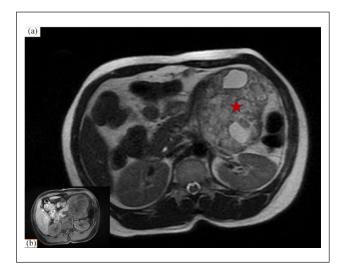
Pancreatic MRI: (a) Axial T2-weighted section showing a well-limited, encapsulated mass in the tail of the pancreas, with a dual component: cystic in frank hypersignal and tissular in intermediate signal. (b) T1FS axial sections without and with gadolinium injection, showing enhancement of the fleshy portion of the mass.
